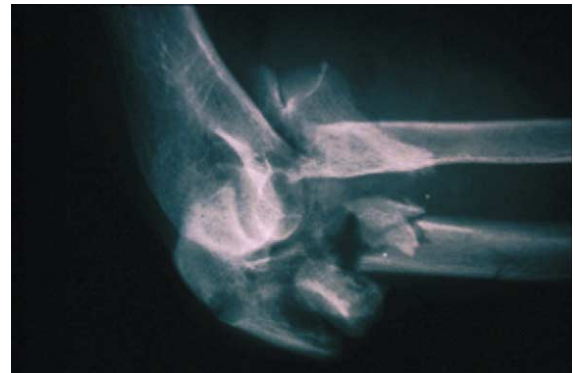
Radiograph of a comminuted elbow fracture caused by a blow from the module cover.
